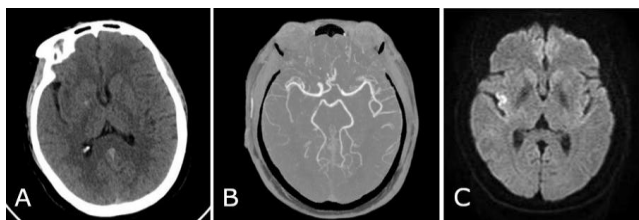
Imaging of the 1st stroke. A. NCCT; B. Distal R-M2 occlusion in CTA; C. MRI 24h post IV r-tPA
